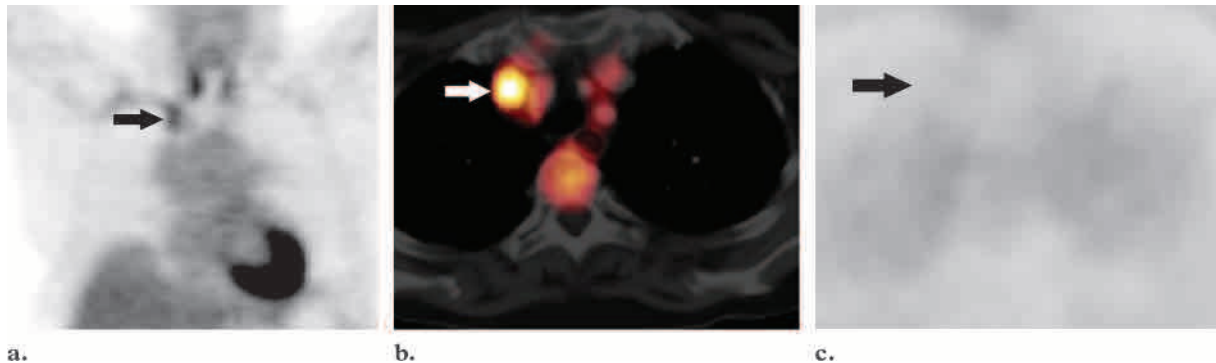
Focal CT attenuation artifact due to high-attenuation intravenous contrast material. (a) Coronal PET scan shows symmetric FDG uptake in the thyroid gland and a focal area of intense uptake in the right supraclavicular region (arrow) mimicking an abnormal lymph node. (b) Axial fused PET-CT scan helps localize the apparent FDG activity precisely to the brachiocephalic vein (arrow). (c) On an axial uncorrected emission image, no apparent FDG activity is seen (arrow), indicating that the area of uptake seen at fused PET-CT represents an artifact of CT-based attenuation correction.
